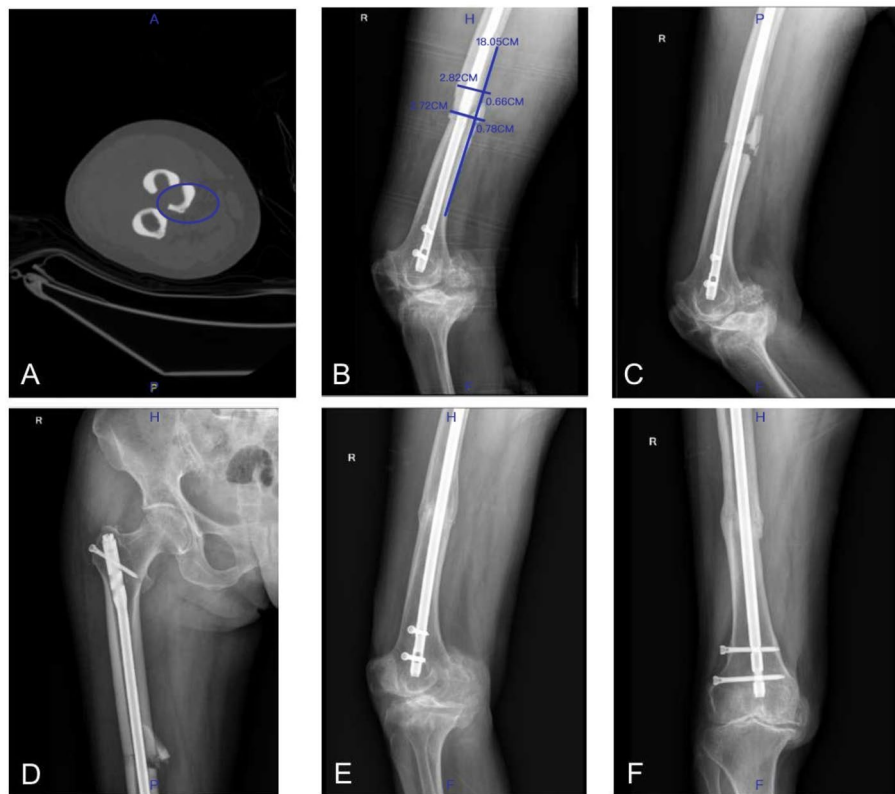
A 69-year-old female patient presented with a right femoral shaft fracture caused by a car accident, classified as degree I displaced with type 2 circumference, which was treated with intramedullary nails 4 days after injury (A) Preoperative CT tomography showed type 2 circumferential fracture of femoral shaft; (B) postoperative X-ray showed degree I displaced fracture of femoral shaft; (C, D) anteroposterior and lateral X-ray at 1 months after operation showed clear fracture line between the fracture ends; (E, F) anteroposterior and lateral X-ray at 13 months after operation showed blurred fracture line at the fracture ends, with bridging callus production.
